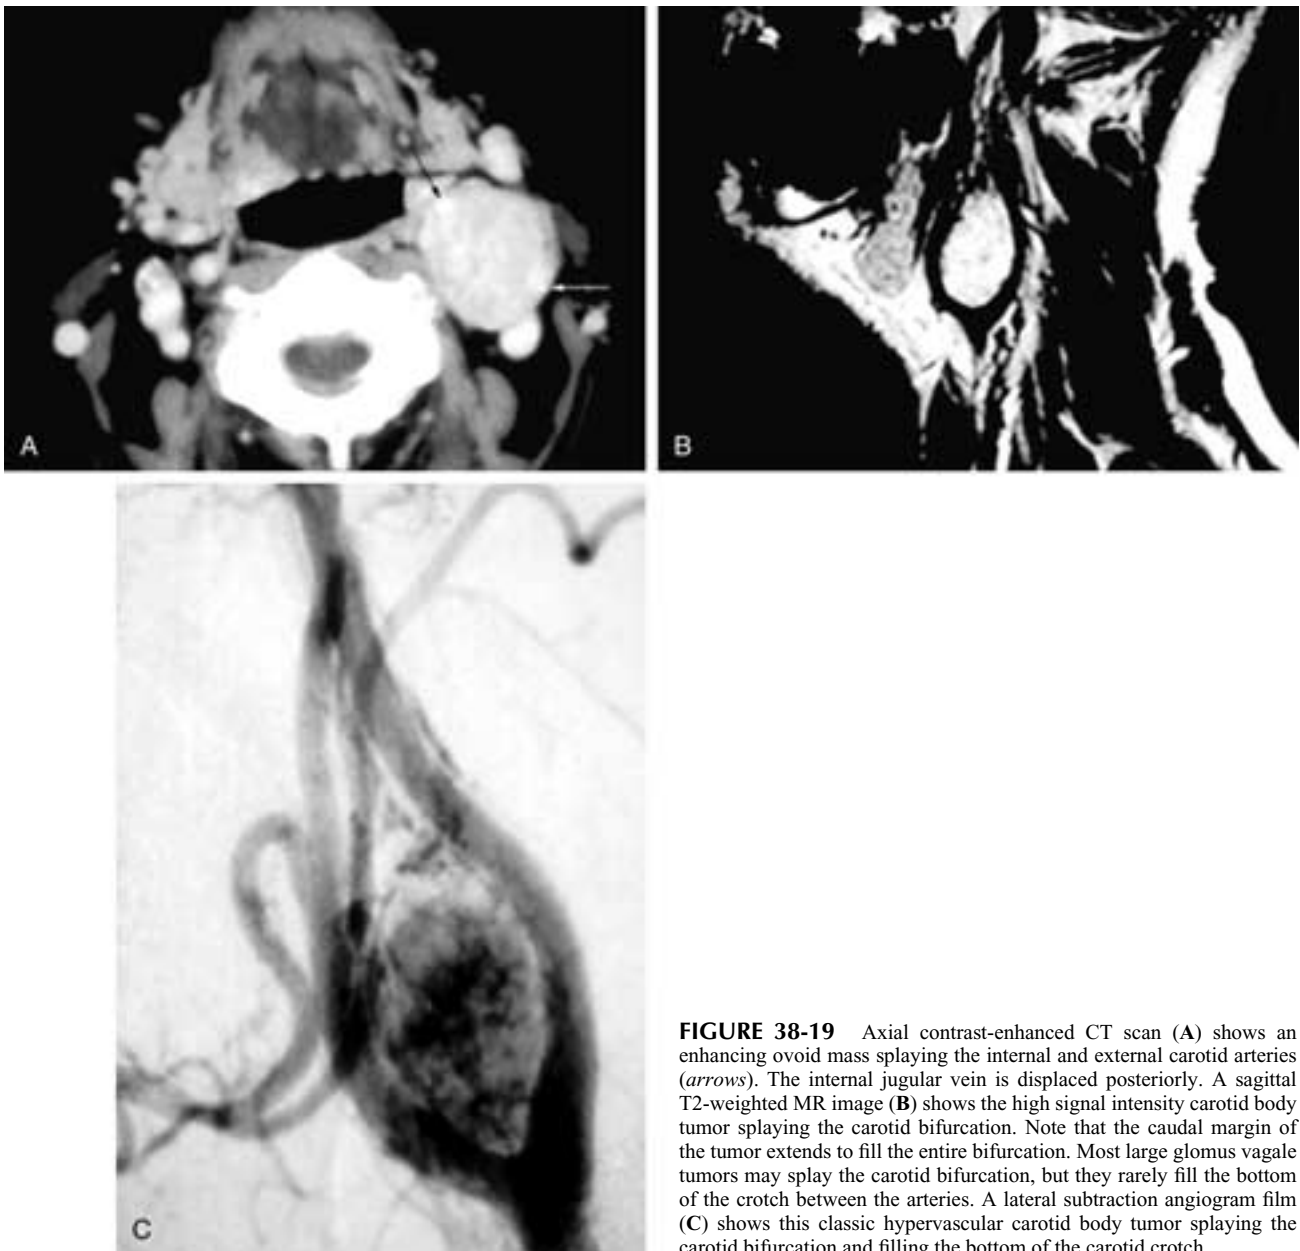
Axial contrast-enhanced CT scan (A) shows an enhancing ovoid mass splaying the internal and external carotid arteries (arrows). The internal jugular vein is displaced posteriorly. A sagittal T2-weighted MR image (B) shows the high signal intensity carotid body tumor splaying the carotid bifurcation. Note that the caudal margin of the tumor extends to fill the entire bifurcation. Most large glomus vagale tumors may splay the carotid bifurcation, but they rarely fill the bottom of the crotch between the arteries. A lateral subtraction angiogram film (C) shows this classic hypervascular carotid body tumor splaying the carotid bifurcation and filling the bottom of the carotid crotch.
